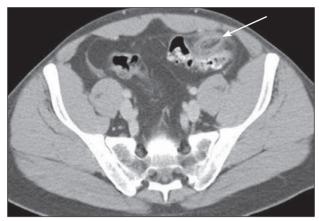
This axial contrast-enhanced CT image shows an ovalshaped fat density (white arrow) with a hyperattenuating rim and surrounding fat-stranding abutting the sigmoid colon, without colonic wall thickening.
